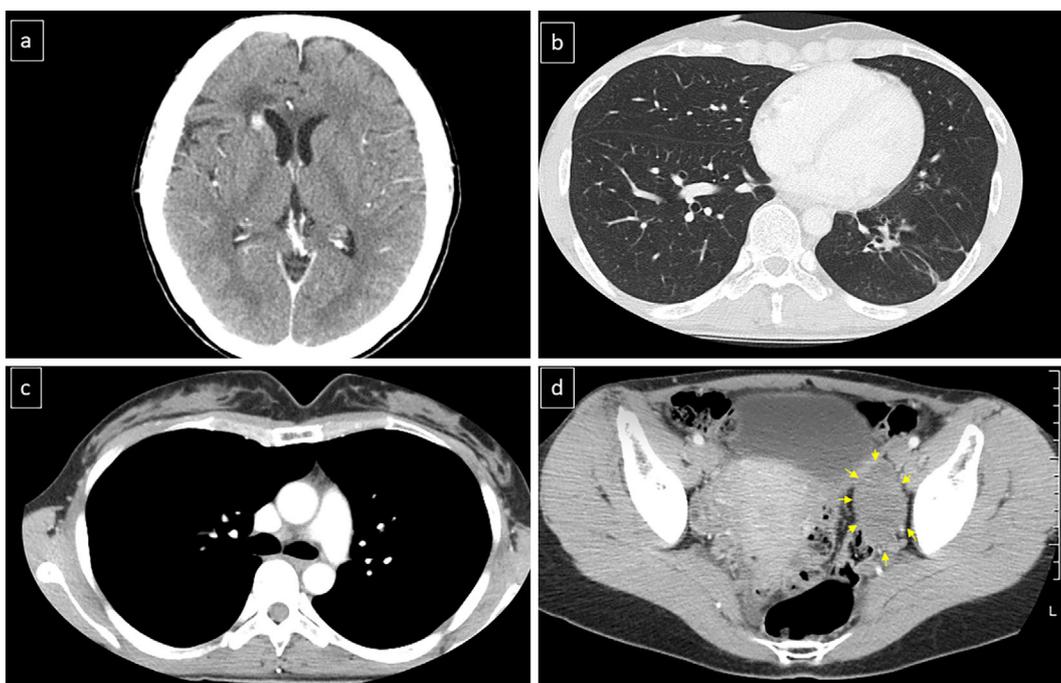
Contrast-enhanced computed tomography at 20 months after the initiation of alectinib treatment. The volume of each tumor was remarkably reduced: a) brain , b) lung, c) mediastinal lymph node, and d) left ovary (yellow arrows).
